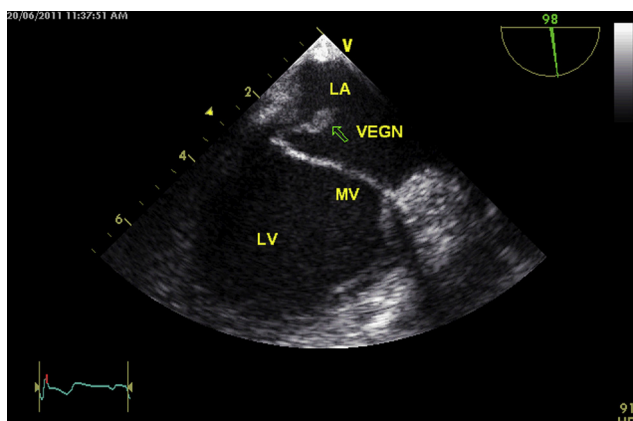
Transesophageal echocardiogram showing large vegetation on the mitral leaflet prolapsing into the left atrium.
